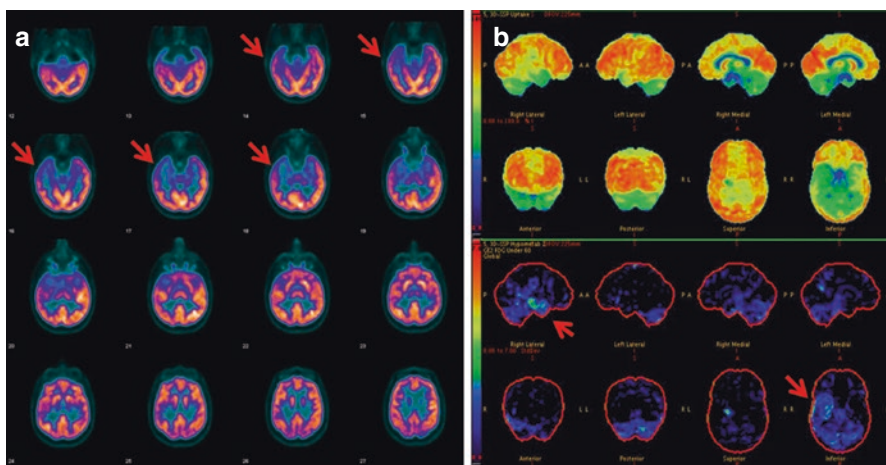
(a, b) Patient evaluated for right hemispheric epilepsy. Axial FDG PET images (a) and Z-score maps (b) show right temporal lobe hypometabolism (a, arrows) which is confirmed on quantification assessment (b, arrows), in keeping with an epileptogenic focus.
